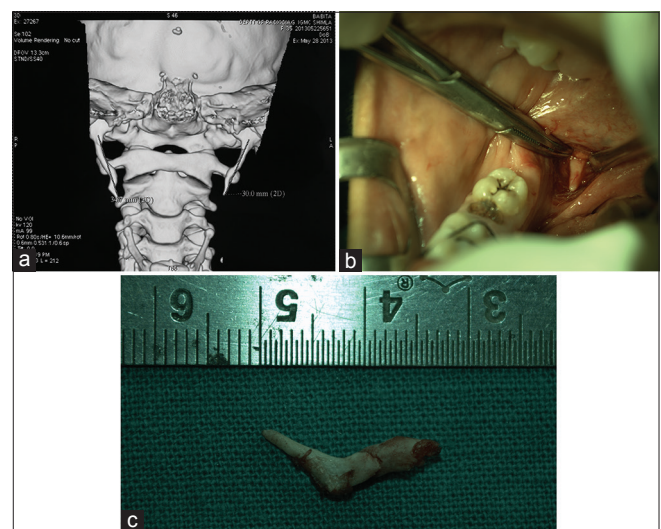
(a) Computed tomography shows right and left elongated styloid process of size 34.7 mm and 30 mm, respectively. (b) Intraoperative photograph showing surgical excision of the right styloid process through transoral approach. (c) Excised right elongated styloid process
